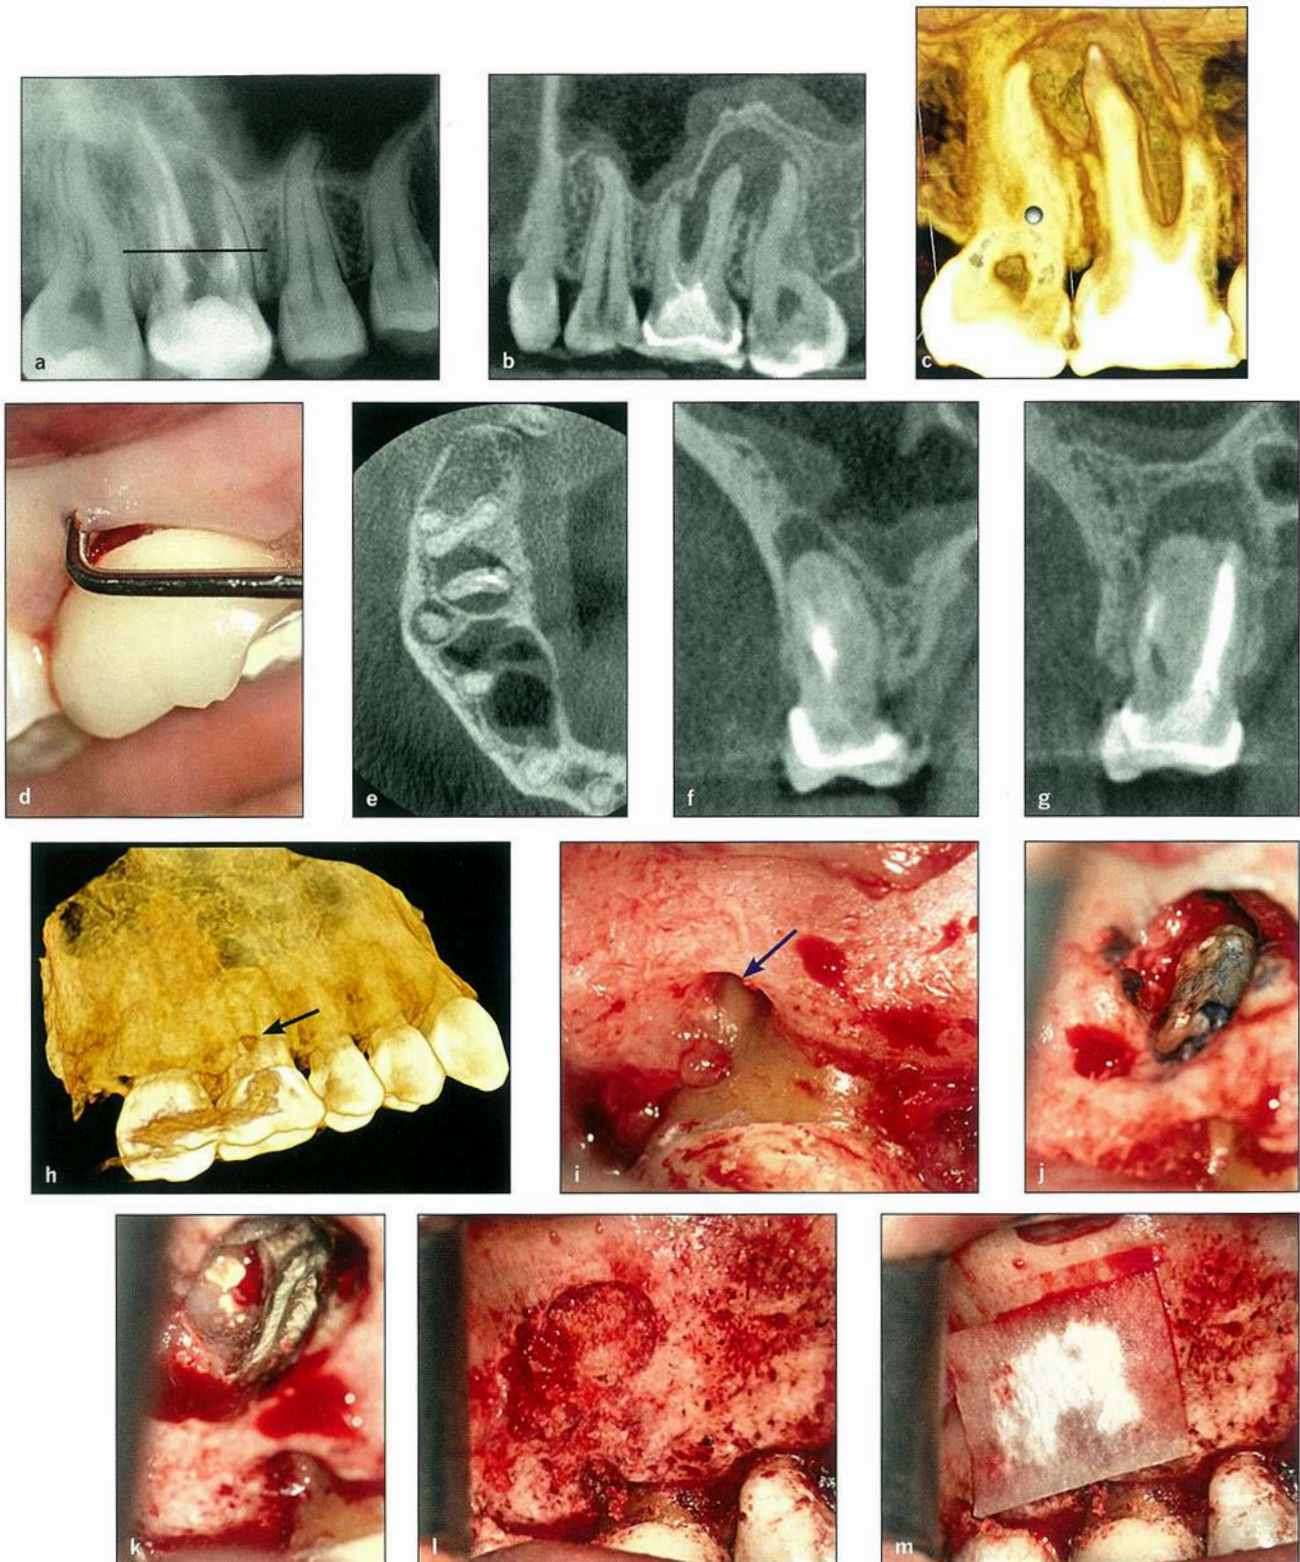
(a) Periapical radiograph of a maxillary first molar that was referred for periapical surgery. A nonsurgical retreatment attempt was performed prior to periapical microsurgery, but the mesiobuccal canal was blocked. The *black line* in *a* corresponds to the level of the axial view in *e*. (b) Sagittal view demonstrating the extent of the periapical defect. (c) Three-dimensional (3D) rendering of the periapical defect. (d) Clinical photograph demonstrating the endodontic-periodontal communication. (e) Axial view of the mesiobuccal, distobuccal, and palatal roots. Note the fused distal and palatal roots. (f and g) Coronal views of the mesiobuccal root and the fused distal-palatal roots. (h) 3D rendering demonstrating the periodontal defect (*black arrow*). (i) After full-thickness flap reflection, the periodontal defect was determined to communicate with the periapical defect (*blue arrow*). (j) Root resection of the fused distal-palatal roots prior to ultrasonic preparation. (k) MTA root-end filling of the ultrasonically prepared distal and palatal preparation. (l) Periodontal and periapical defects grafted with Puros allograft material (Zimmer). (m) Grafted defect covered with a CopiOs membrane (Zimmer). →
